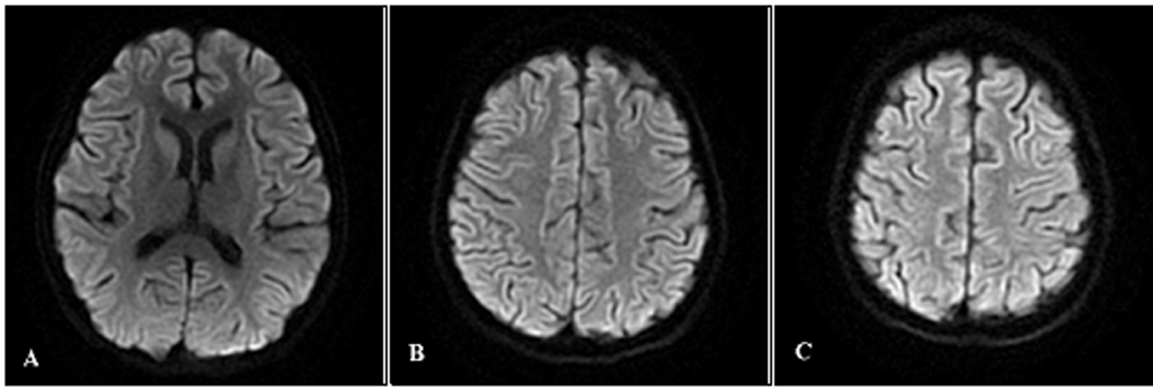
Follow-up 3.0-T MRI about 3 weeks later indicated that the DWI signal hyperintensities had disappeared completely in the splenial (A) and cortical lesions (B and C).
